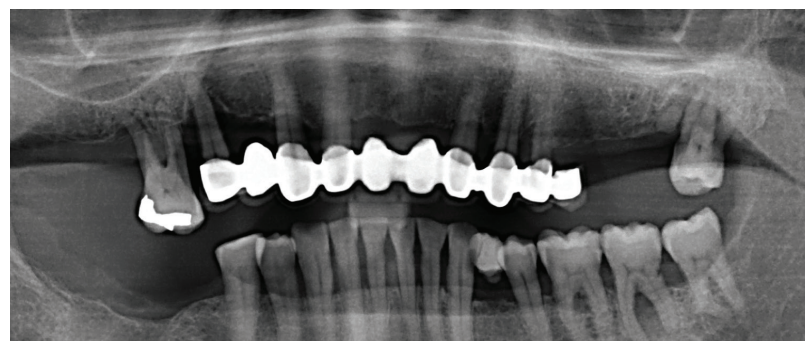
Pre-operative smile and orthopantomogram.
